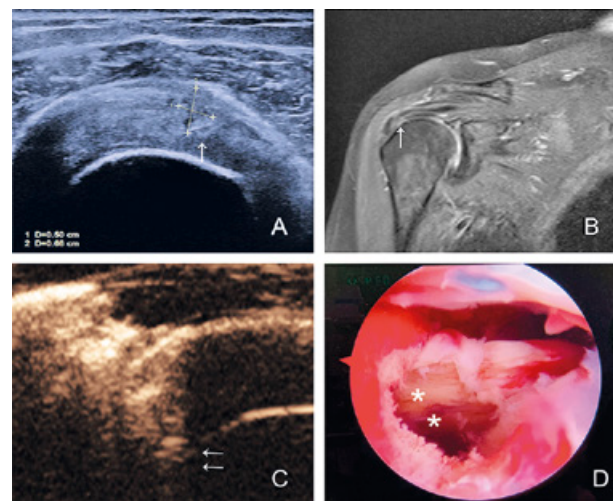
US, MRI, PUBS, and shoulder arthroscopic images of a 65-year-old woman with full-thickness tear: (A) US revealed a partial-thickness tear of the supraspinatus tendon on the bursal side that did not reach the articular surface (↑); (B) The T2 image of MRI indicated the presence of high signal in the supraspinatus tendon (↑), which did not penetrate the whole layer; (C) PUBS showed that contrast agent flowed from the defect of the supraspinatus tendon bursal to the articular side (↑) and reached the articular cavity, suggesting a full-thickness supraspinatus tear. (D) Arthroscopy showed a full-thickness tear of the supraspinatus tendon.
